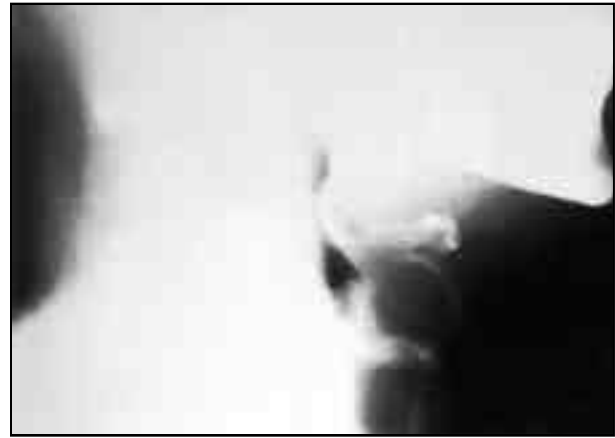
X-ray soft tissue neck showing epiglottic cyst
